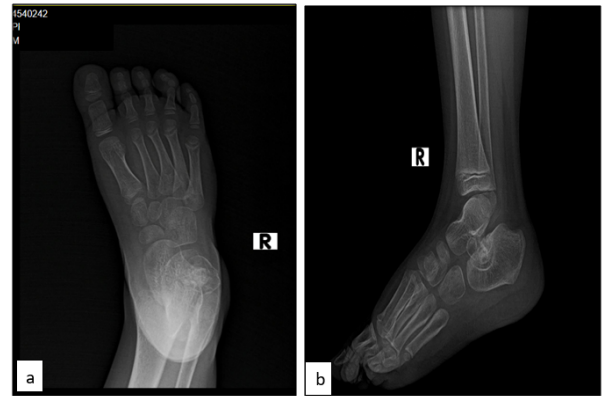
Plain x-ray radiographs showing a): AP view and b): Showing lateral view of the right ankle
